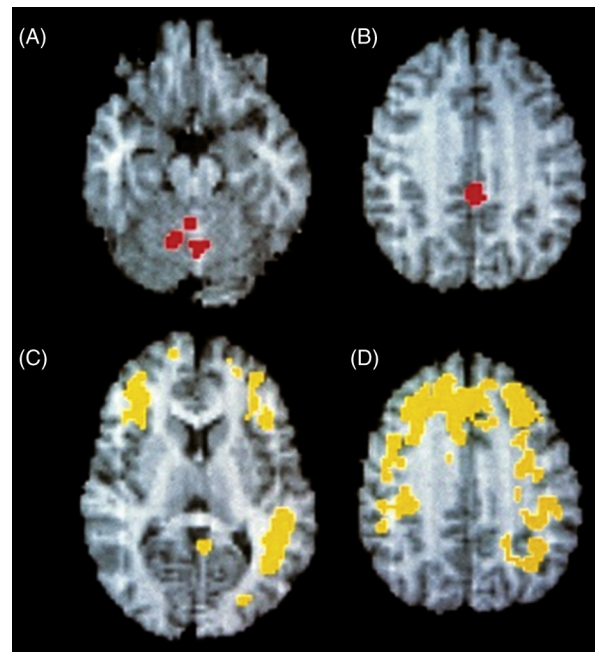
SPECT findings in a 22-year old man with familial SW (with permission from Bassetti and Vadiolonga, 2000). The highest increases of regional cerebral blood flow (>25%) during SW compared with quiet stage 3 to 4 NREM sleep are found in the anterior cerebellum—i.e., vermis (A), and in the posterior cingulate cortex (Brodmann area 23 [Tallarich coordinate $x = -4$, $y = -40$, $z = 31$], (B)). However, in relation to data from normal volunteers during wakefulness ($n = 24$), large areas of frontal and parietal association cortices remain deactivated during SW, as shown in the corresponding parametric maps (z -threshold = -3). Note the inclusion of the dorsolateral prefrontal cortex (C), mesial frontal cortex (D) and left angular gyrus (C) within these areas.
